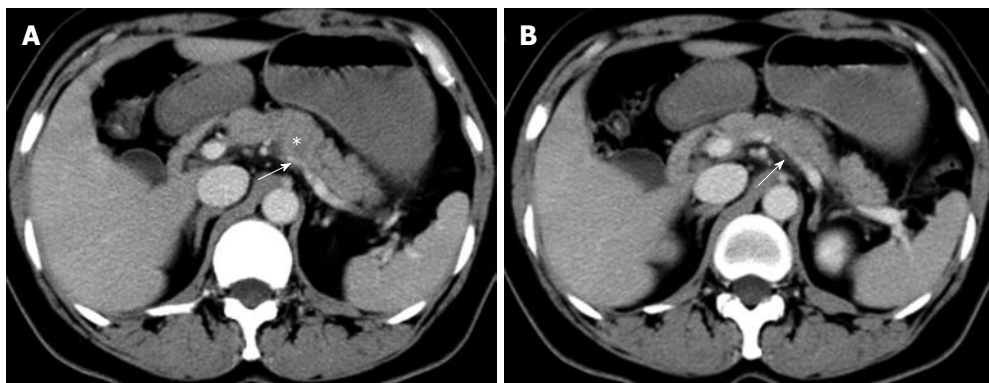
Patterns of extrapancreatic neural invasion by pancreatic carcinoma visualized by computed tomography in a 56-year-old female with pancreatic carcinoma in the pancreas body. Contrast-enhanced computed tomography images (A, B) show the splenic plexus invasion (arrows) by the tumor (asterisk) in the body of pancreas. The appearance of plexus invasion is streaky structure.
